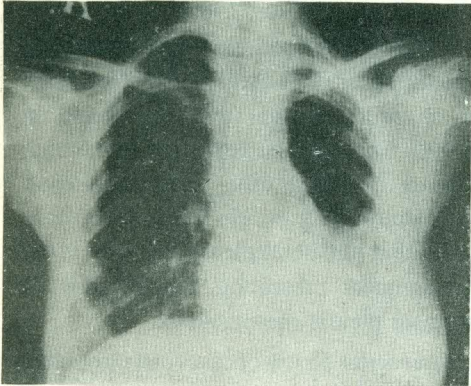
X-ray of a case with malignant pleural thickening without pleural effusion.
